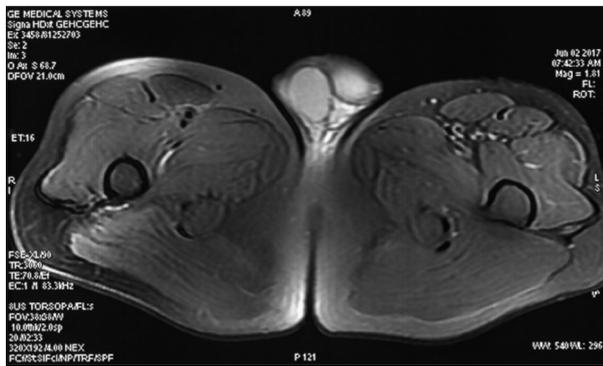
Magnetic resonance imaging (MRI) of the lower extremities. Images were acquired at the level of the upper femur. The T2WI fat suppression sequence showed slight atrophy and suspicious inflammatory changes of the left lateral femoral muscle and tensor fascia lata.
